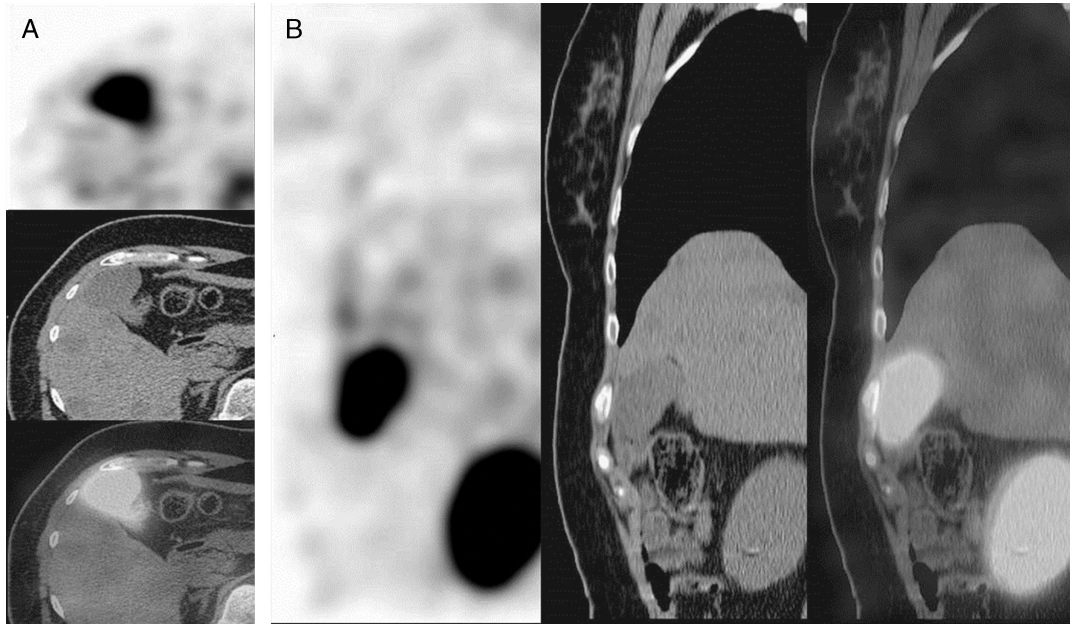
SPECT/CT imaging was performed to localize and accurately characterize planar abnormalities in 3 dimensions. Images confirmed tracer uptake in the body of the 11th thoracic vertebra and showed its heterogeneous aspect without patent morphological characteristics suspicious for metastases on CT scan. No additional foci of abnormal ^{99m}Tc -HMDP uptake were identified on the remainder of the skeleton. Otherwise, axial (A) and coronal (B) SPECT, CT, and fused SPECT/CT images depicted intense, homogenous, and diffuse uptake within the gallbladder lumen. Radiopharmaceutical (HMDP) quality control revealed no radiochemical impurities. Ten other patients received doses from the same vial on the same day with normal distribution. This incidental accumulation of ^{99m}Tc -HMDP could be readily explained by metabolic pathway such as chronic lithiasis.⁴ Furthermore, bevacizumab is known for hepatotoxicity or other digestive side effects, such as gallbladder inflammation or perforation; however, the patient presented no evidence of toxicity.⁵ However, images did not reveal calcified or inflamed gallbladder wall. Besides, abdominal CT images depicted known liver metastases. The mechanism of gallbladder excretion of derivatives of ^{99m}Tc -diphosphonates is unknown and rare.^{6,7} There are many factors that can alter the normal biodistribution of the radiopharmaceutical and lead to its extraosseous localization. Some authors have suggested a mechanism linked to increased interstitial pressure associated with liver metastases.⁸ In our case, this option seems impossible because of the low-volume metastases, and we believe that gallbladder excretion of ^{99m}Tc -HMDP could be due to an iatrogenic alteration of radiopharmaceutical by chemotherapeutic agents.
